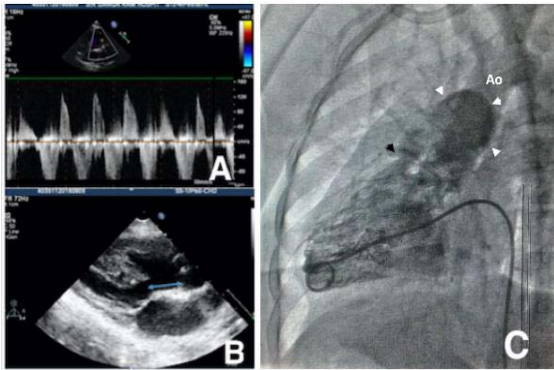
A) Doppler signal across right ventricular outflow tract suggestive of pulmonary stenosis and pulmonary regurgitation, B) Subaortic conus demarcated by double ended arrows, C) Right heart cath study showing the narrow pulmonary annulus (black arrow head) and dilated pulmonary artery (white arrow heads).
